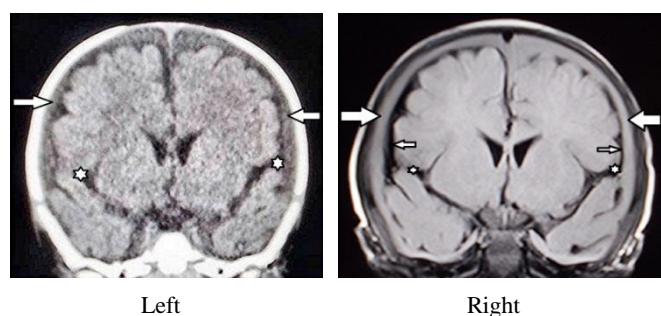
Case 3 (No 9), male aged 6 months. Left: CT (coronal view) on arrival demonstrating bilateral, extra-axial fluid collections with slightly higher intensity than the CSF in the lateral ventricles, indicating ASDHy (arrows). Note the large, bilateral sylvian fissures and the slightly larger size on the left side (stars). Right: MRI (FLAIR, coronal view) obtained 2 days later demonstrating bilateral ASDHy (arrows). Note the large, bilateral sylvian fissures (L>R, star) and bilateral enlargement of the SAS, which is more pronounced on the left side (small arrows). No parenchymal abnormality was found on the other sequences (not shown).
